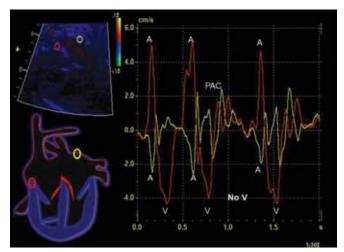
Tissue Doppler (kinetogram) method offers an offline technique of documenting and assessing fetal arrhythmia
